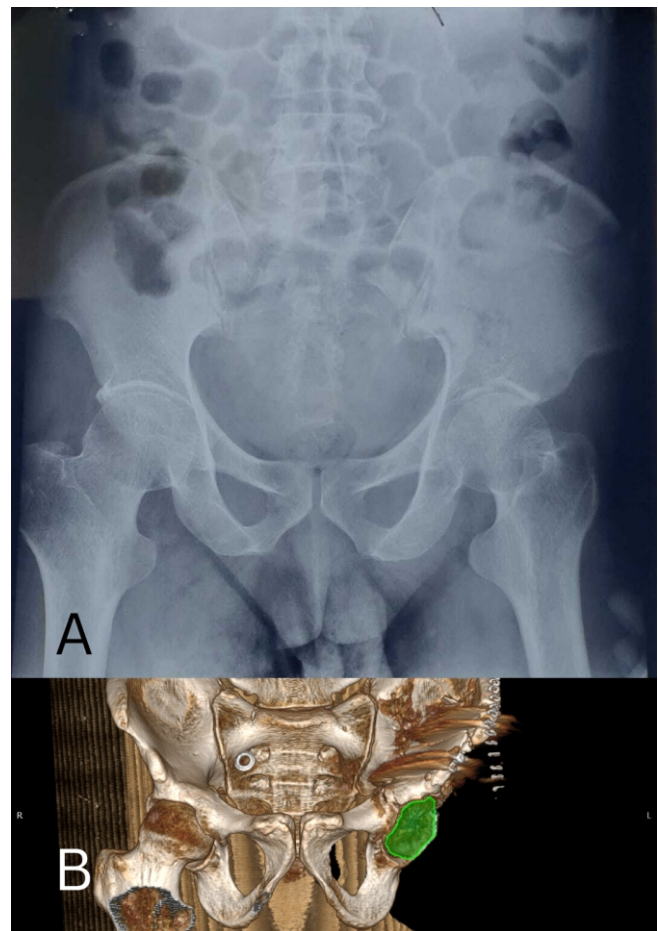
(A) Pre-operative antero-posterior X-ray of the acetabulum showing a superior type fracture of the right acetabulum (B) post operative 3D reconstruction of the pelvis showing superior fracture while respecting continuity of the pelvic ring.
